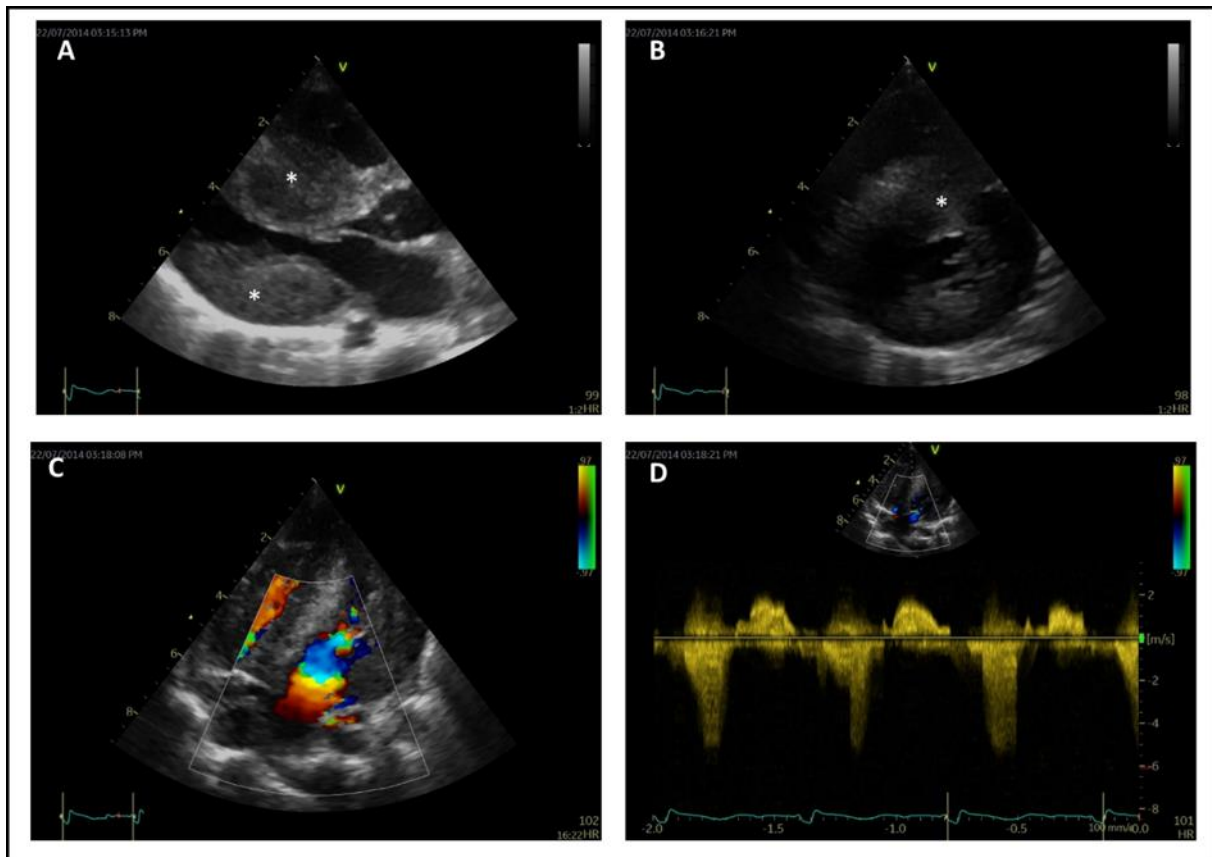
Echocardiographic images of patient 4, Related to Figure 1. Transthoracic echocardiographic imaging of patient 4 (Noonan syndrome, *PTPN11*, female, age 13 months) at the time of admission to the hospital for surgical left ventricular outflow tract resection. Depicted are the parasternal long axis view (panel A), parasternal short axis view (panel B), and the apical 5-chamber view (panel C and D) with color Doppler (panel C) and continuous wave (CW) Doppler (panel D) imaging. There is severe myocardial thickening (*), the peak gradient over the left ventricular outflow tract measures 72 mmHg.
